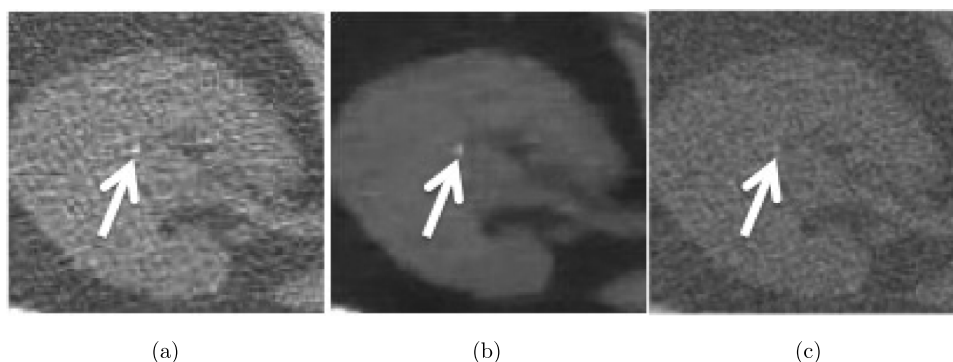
TV-flow results on a right kidney. (a) Original CT image with a small calculus (white arrow), (b) smoothed results using TV-flow ($t = 2$), and (c) smoothed results using Perona's approach (Ref. 36) ($t = 2$).
